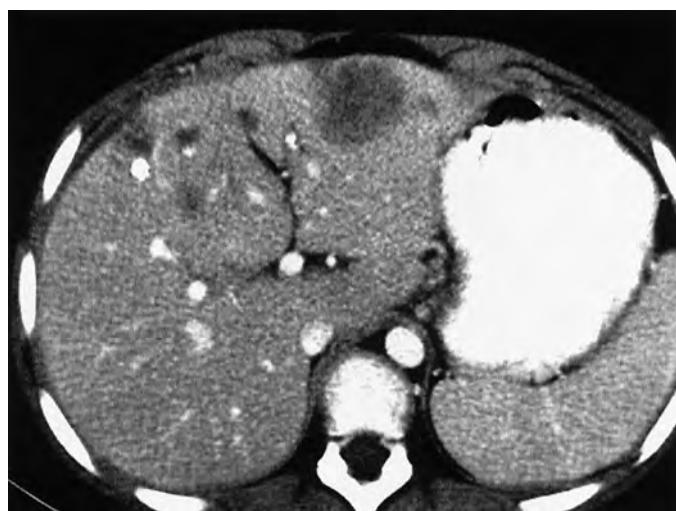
Chronic granulomatous disease. Multiple hepatic lesions are found on the CT scan of a 9-year-old boy. CT demonstrates calcifications from prior infections and low-attenuation masses from an active infection.
